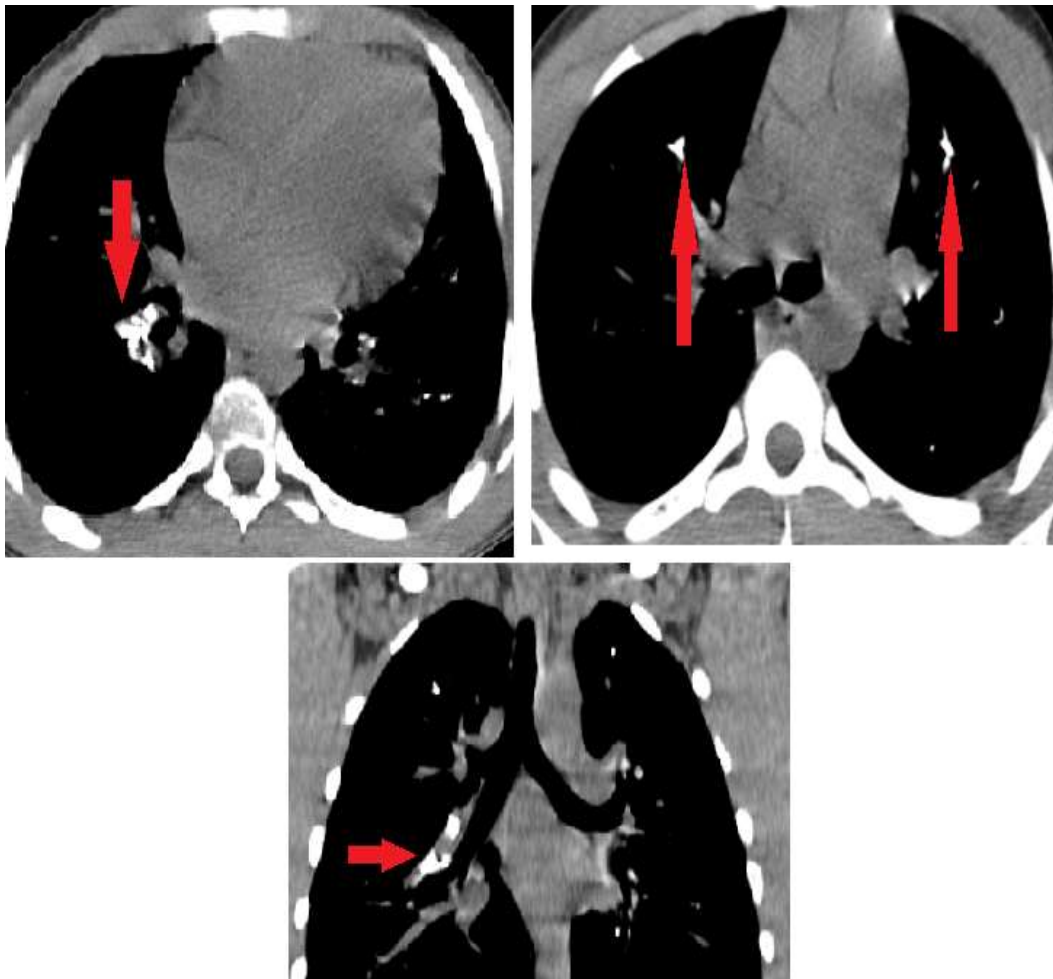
Initial chest CT scan showing spontaneously hyperdense areas of intravascular distribution, in the two pulmonary fields due to the migration of the butyl-cyanoacrylate/lipiodol glue, responsible for pulmonary embolism.
